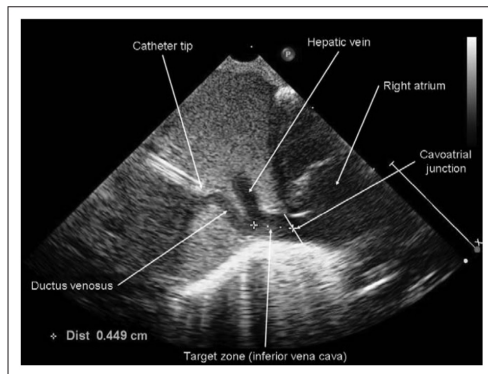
Ultrasound of the target zone (i.e., the length of the inferior vena cava between the insertion of the ductus venosus and the cavoatrial junction) measured as 4.49 mm.
